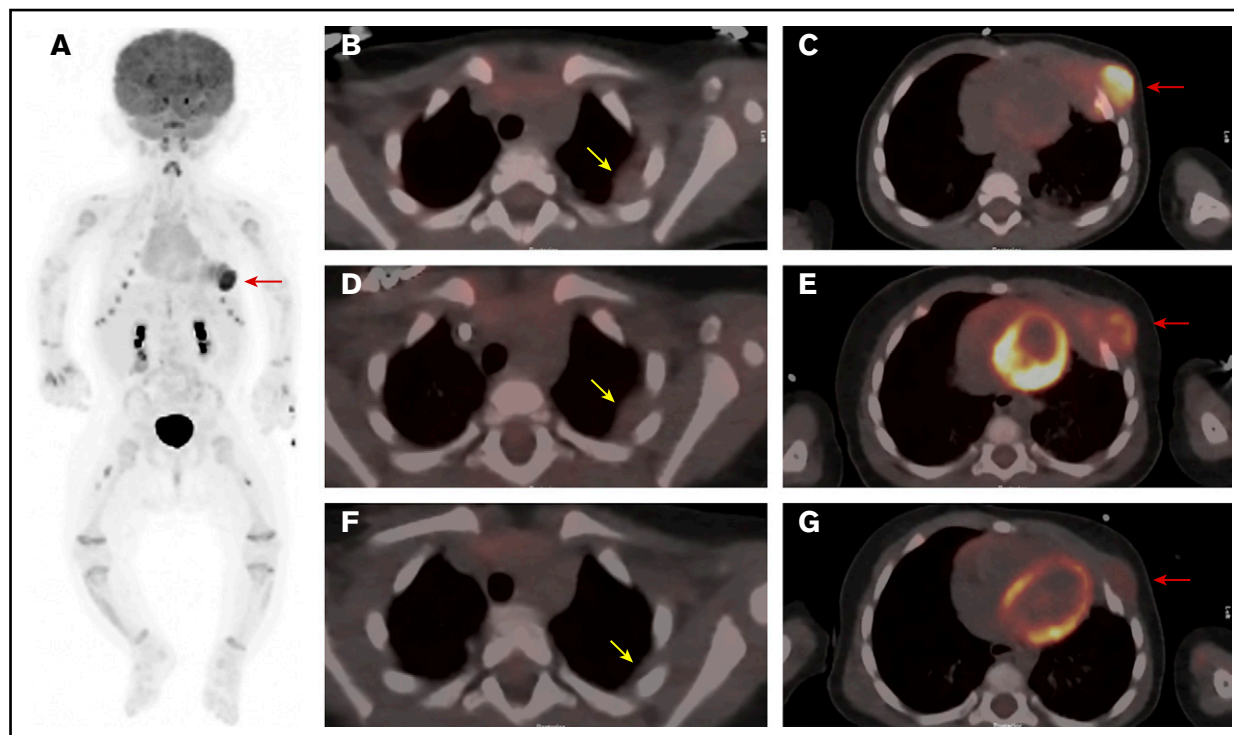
PET/CT scan of the chest at 3 time points. (A) Whole body anterior projection image from FDG PET/CT scan at diagnosis. Red arrow points to the FDG-avid left-sided chest wall mass. Sites of soft tissue uptake in both thighs represent injection sites from recent immunizations. Transverse fusion PET/CT sections through the thorax at baseline (B-C), following upfront standard therapy with vinblastine and steroids (D-E), and after therapy with dasatinib (F-G). At baseline, the mass extends into the subcutaneous fat of the left chest wall anteriorly and abuts the pericardium (C). The response to standard therapy was suboptimal with only mild reduction in size and FDG uptake (D-E). (G) Marked reduction in size as well as FDG avidity in response to dasatinib therapy. Yellow arrows point to sites of pleural thickening that were not FDG avid (1.4×1.8 cm). Note that the appearance of the pleural thickening did not change after standard therapy, but nearly resolved following dasatinib. Red arrows point at the large left-chest wall mass centered at the left anterior fourth and fifth ribs and causing rib destruction.
